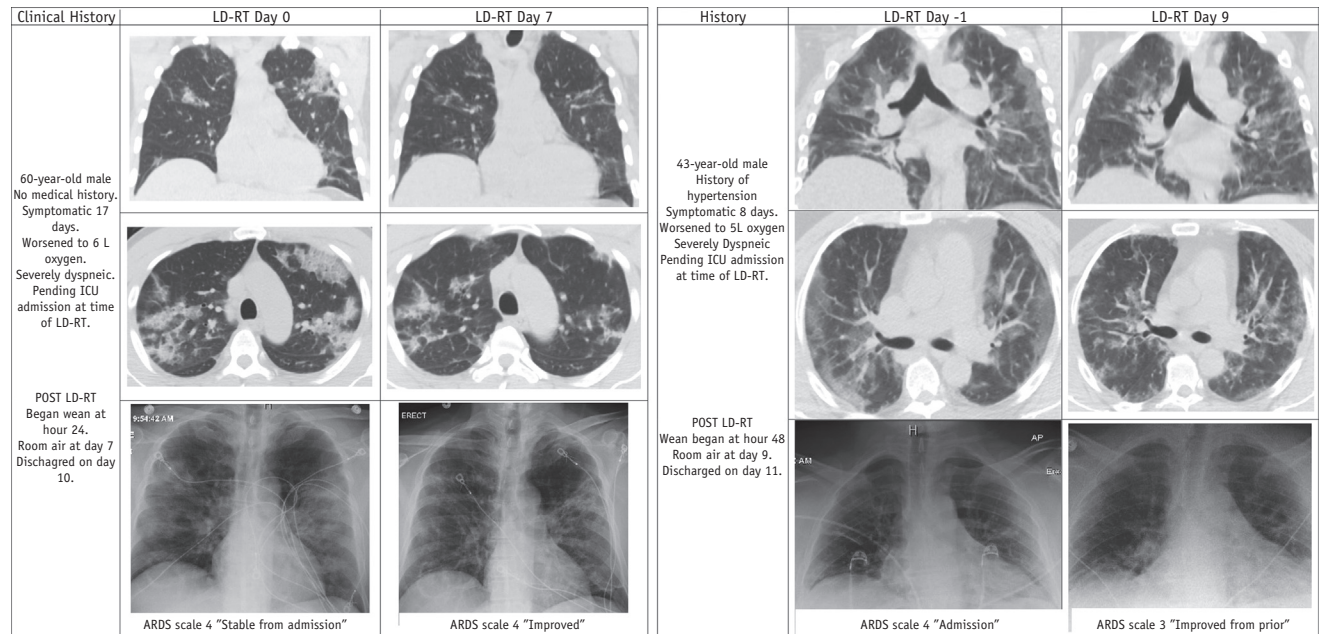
Radiographic improvements after low-dose whole-lung radiotherapy (LD-RT).
